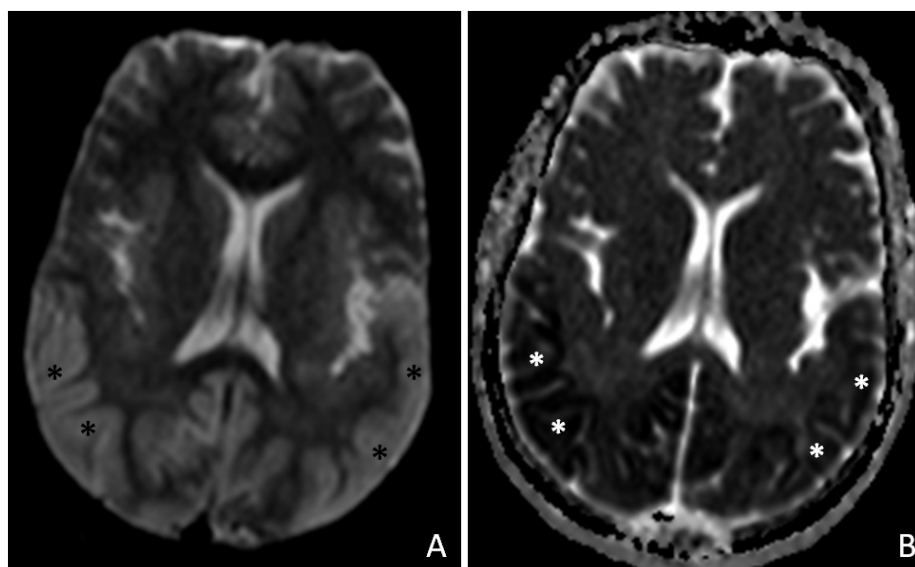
A diffusion-weighted axial MRI image (A, asterisk) reveals hyperintensities in the corresponding regions. The accompanying lower ADC values is noted as dark signals on ADC map (B, asterisk).
